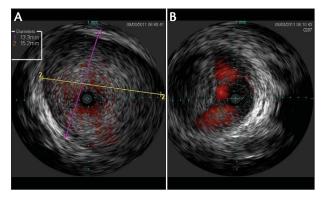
The use of intravascular ultrasound has recently been incorporated into our protocol. It allows clear visualization of the thrombotic material within the venous lumen before (A) and after therapy, minimizing the use of iodinated contrast, as well as allowing precise venous caliber measurements (B). The latter is very useful in cases when angioplasty or stenting are needed to achieve optimal results.
